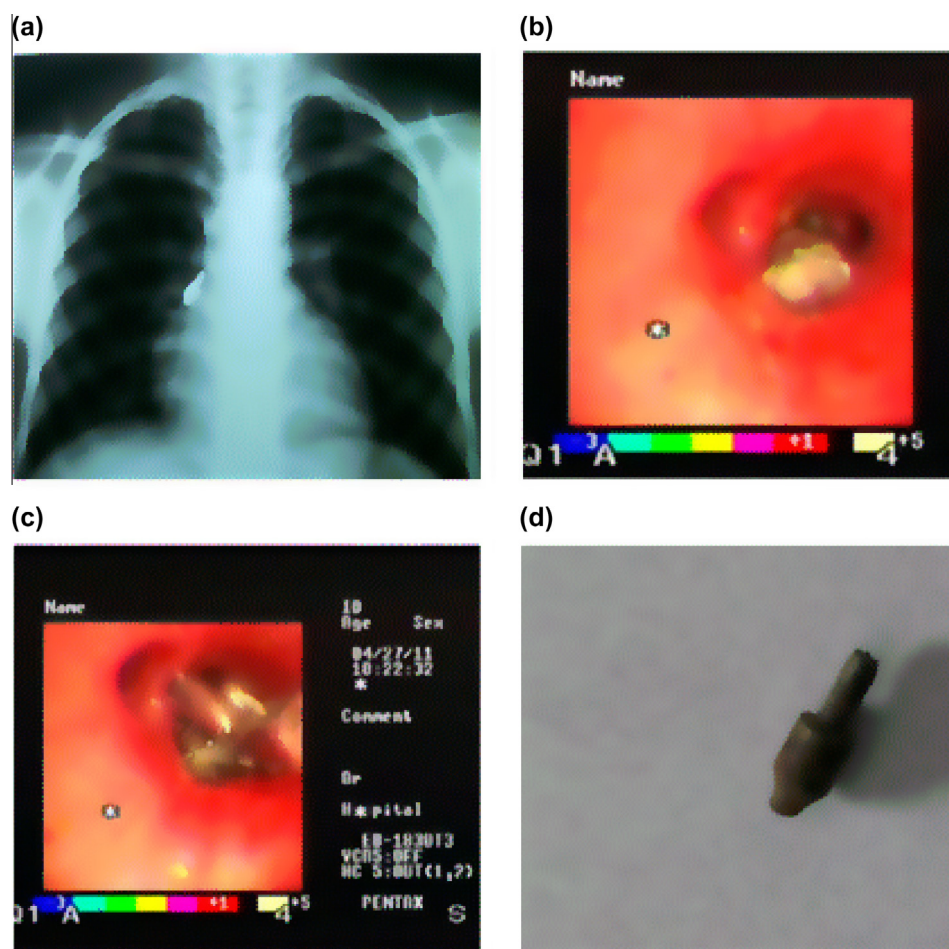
(a) Chest X-ray shows a metal FB. (b) Bronchoscopic image shows the metal FB lodged in the right lower lobe bronchus. (c) Bronchoscopic image shows the forceps grasping the upper head of the metal FB. (d) Picture of the metal FB after removal by flexible bronchoscopy.
